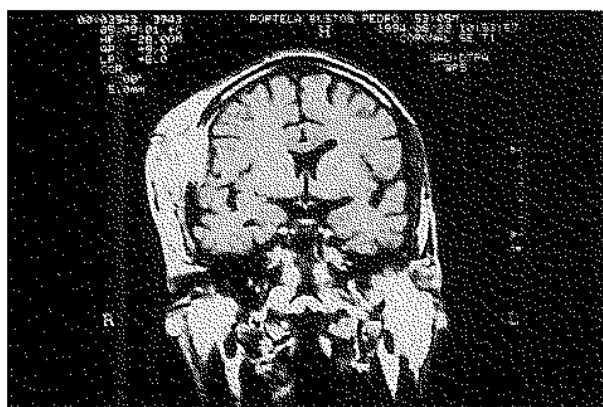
Coronal MRI view of the head showing the infiltrating scalp lesion.
